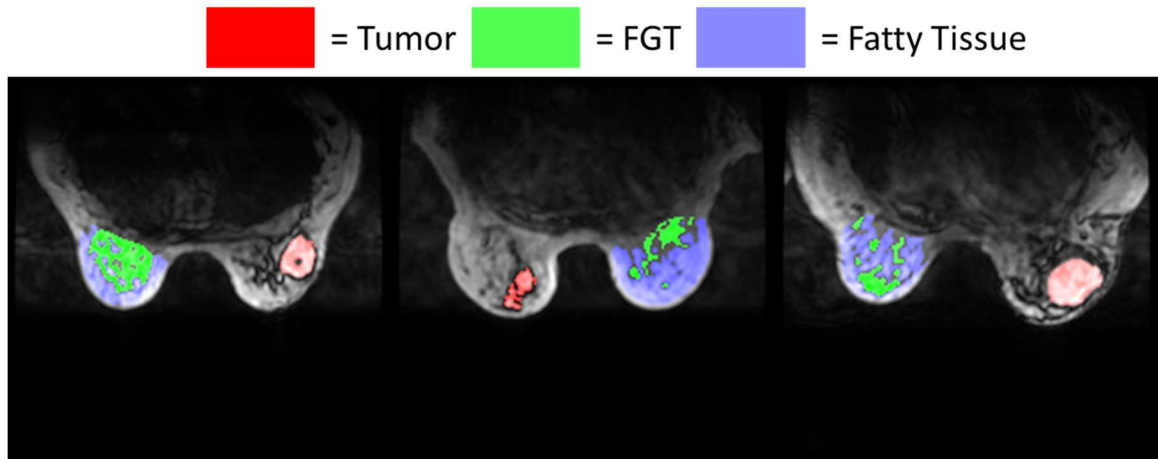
Examples of tissue contouring for three patient pretreatment scans on T1-weighted MRE magnitude images.
